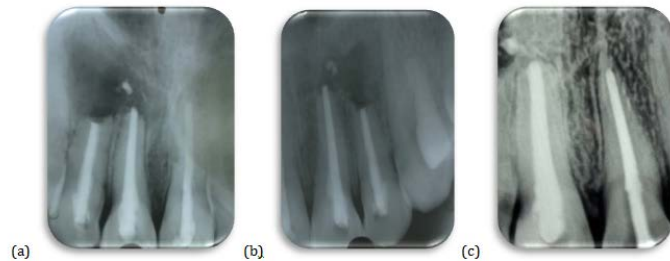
Radiographs of case: (a) 1 month Postoperative radiograph after apicocetomy; (b) 3 months postoperative radiograph showing bone healing; (c) 6 months postoperative radiograph
